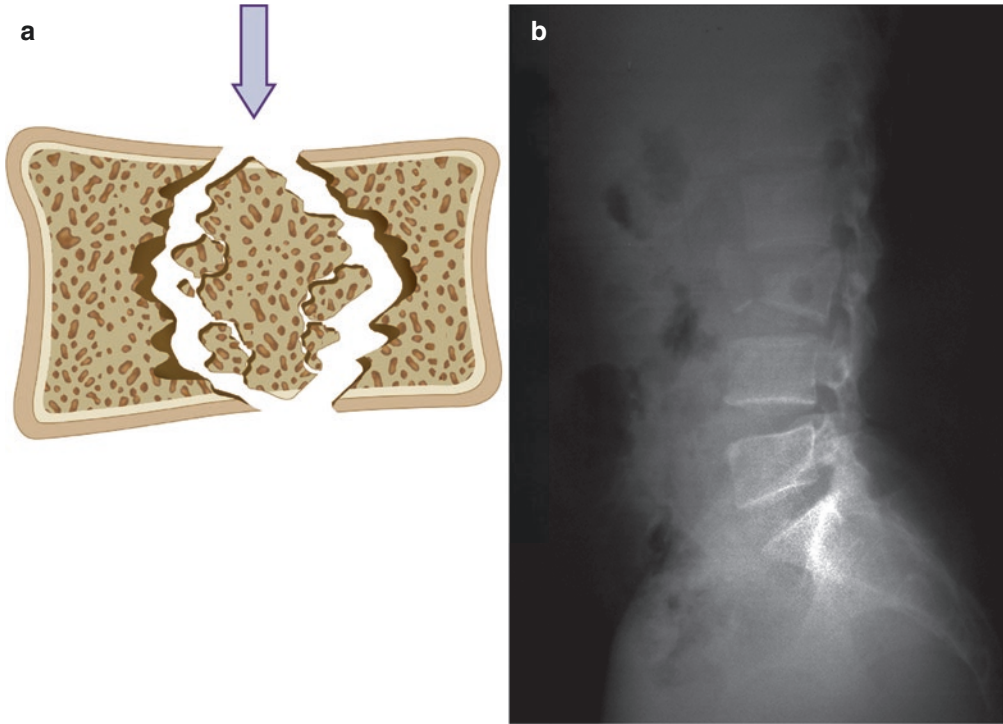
(a) Axial load leads to compression or burst fracture. (b) Lateral X-ray of burst fracture of L3
